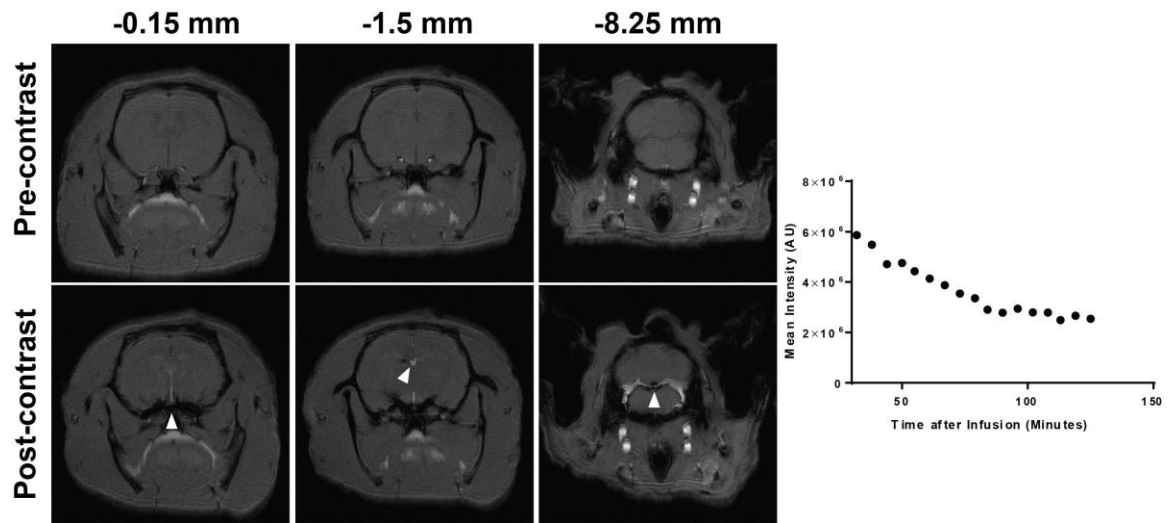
12 Tesla dynamic contrast enhanced MRI cisternography with ferumoxytol. Left, representative T1-weighted coronal sections showing intracranial distribution of ferumoxytol tracer in the CSF. Arrows indicate cisternal and ventricular compartments displaying changes in signal intensity. Right, proof of principle for dynamic cisternal distribution of ferumoxytol after injection of ferumoxytol in the cisterna magna.
